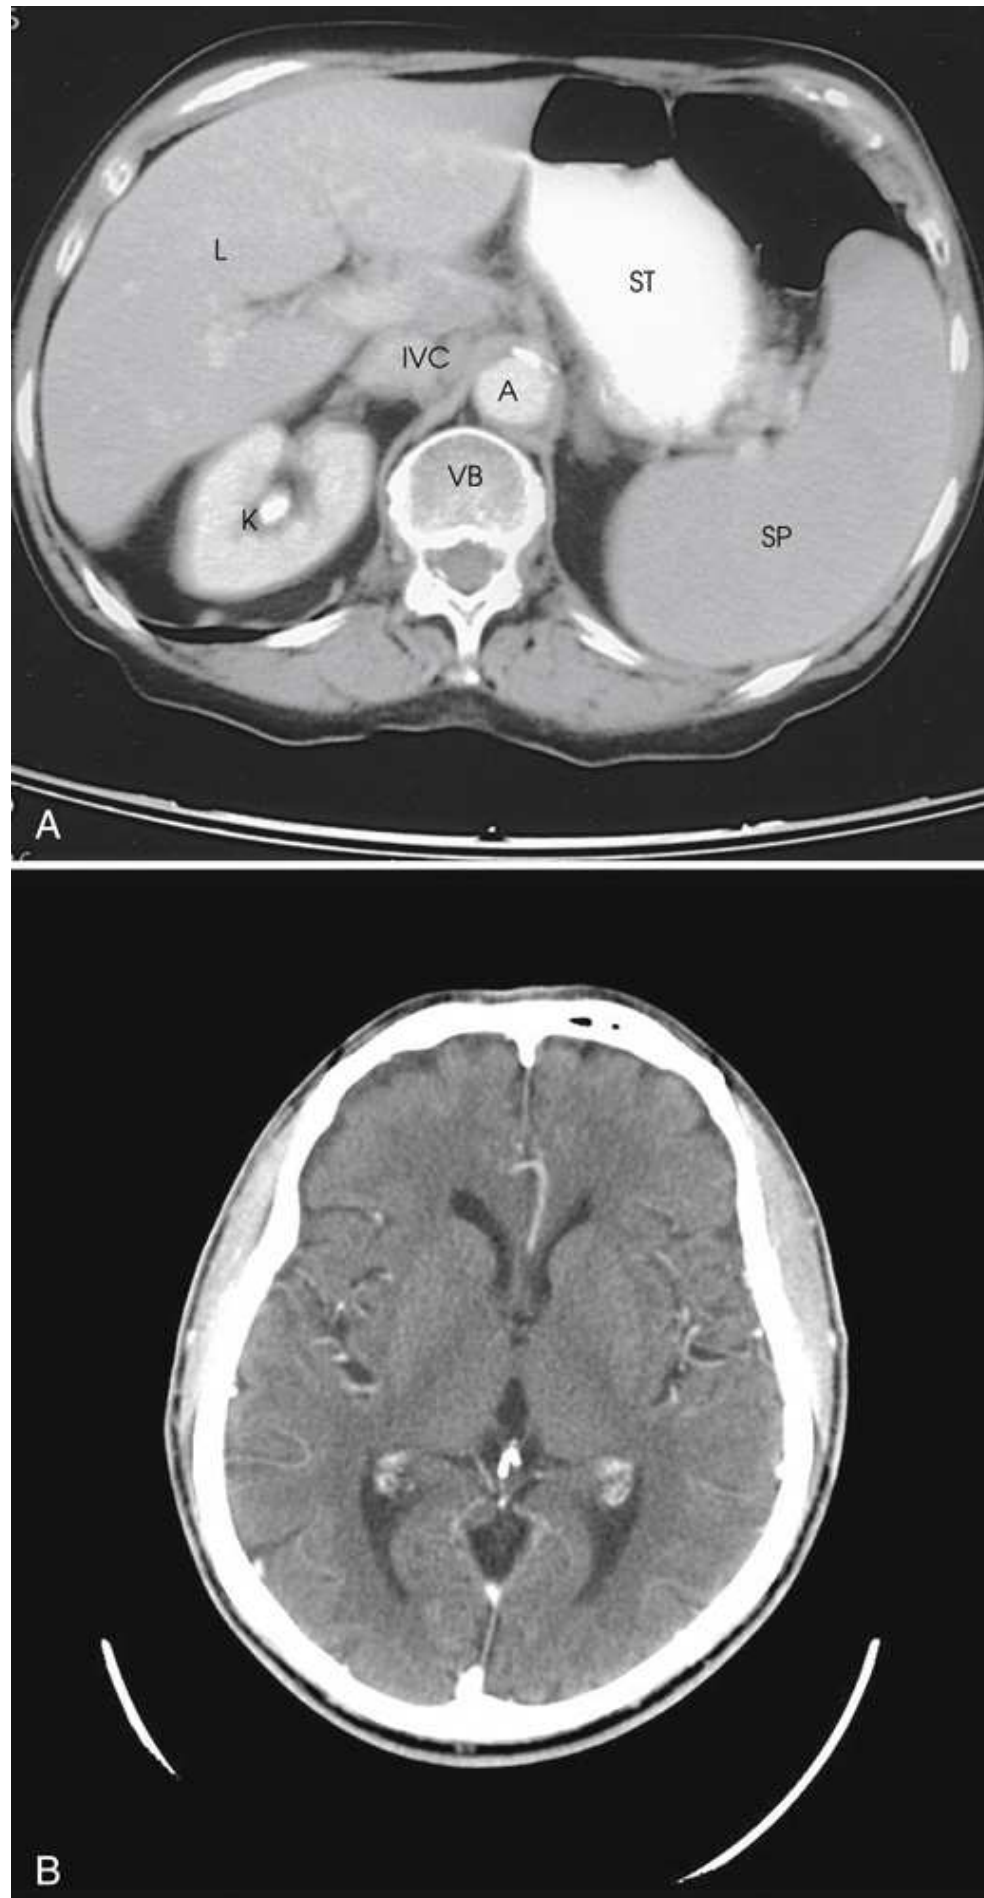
(A) Axial image of abdomen showing liver (L), stomach (ST), spleen (SP), aorta (A), inferior vena cava (IVC), vertebral body of thoracic spine (VB), and kidney (K). (B) Axial CT scan of lateral ventricles— anterior horns (RightALV), posterior horns (LeftPLV), and third ventricle (3V). B, From Kelley LL, Peterson CM: *Sectional anatomy for imaging professionals*, ed 2, St Louis, 2007, Mosby.
